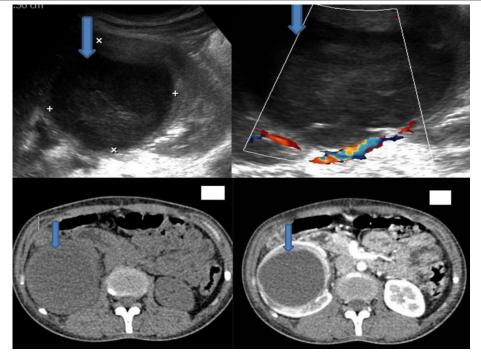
Abscess: Well defined cystic lesion with internal echoes no vascularity on Doppler. On CT appearing hypodense with peripheral contrast enhancement
